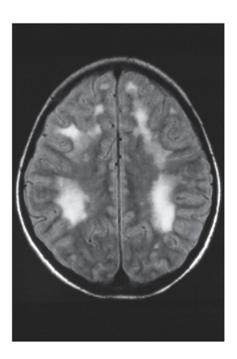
MRI scan of the brain of a nine-year-old with HMG-CoA lyase deficiency. There was extensive increase in signal in the subcortical white matter consistent with dysmyelination. (Kindly provided by Dr Robert Schwartz of Brown University School of Medicine.)
